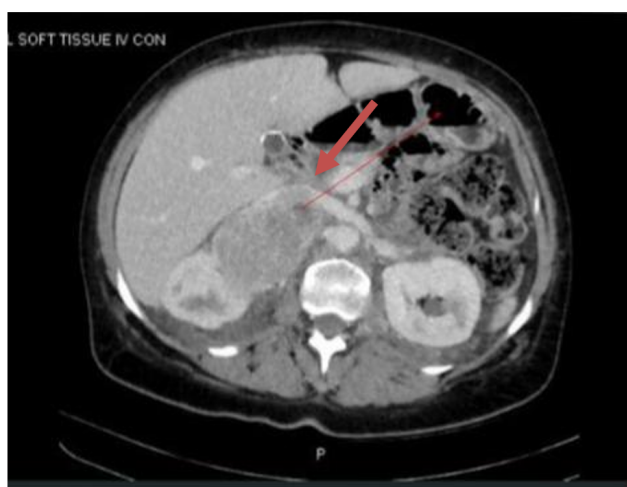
CT showing large right adrenal tumour nearly 12 cm in size – at the time of initial pheochromocytoma diagnosis.
